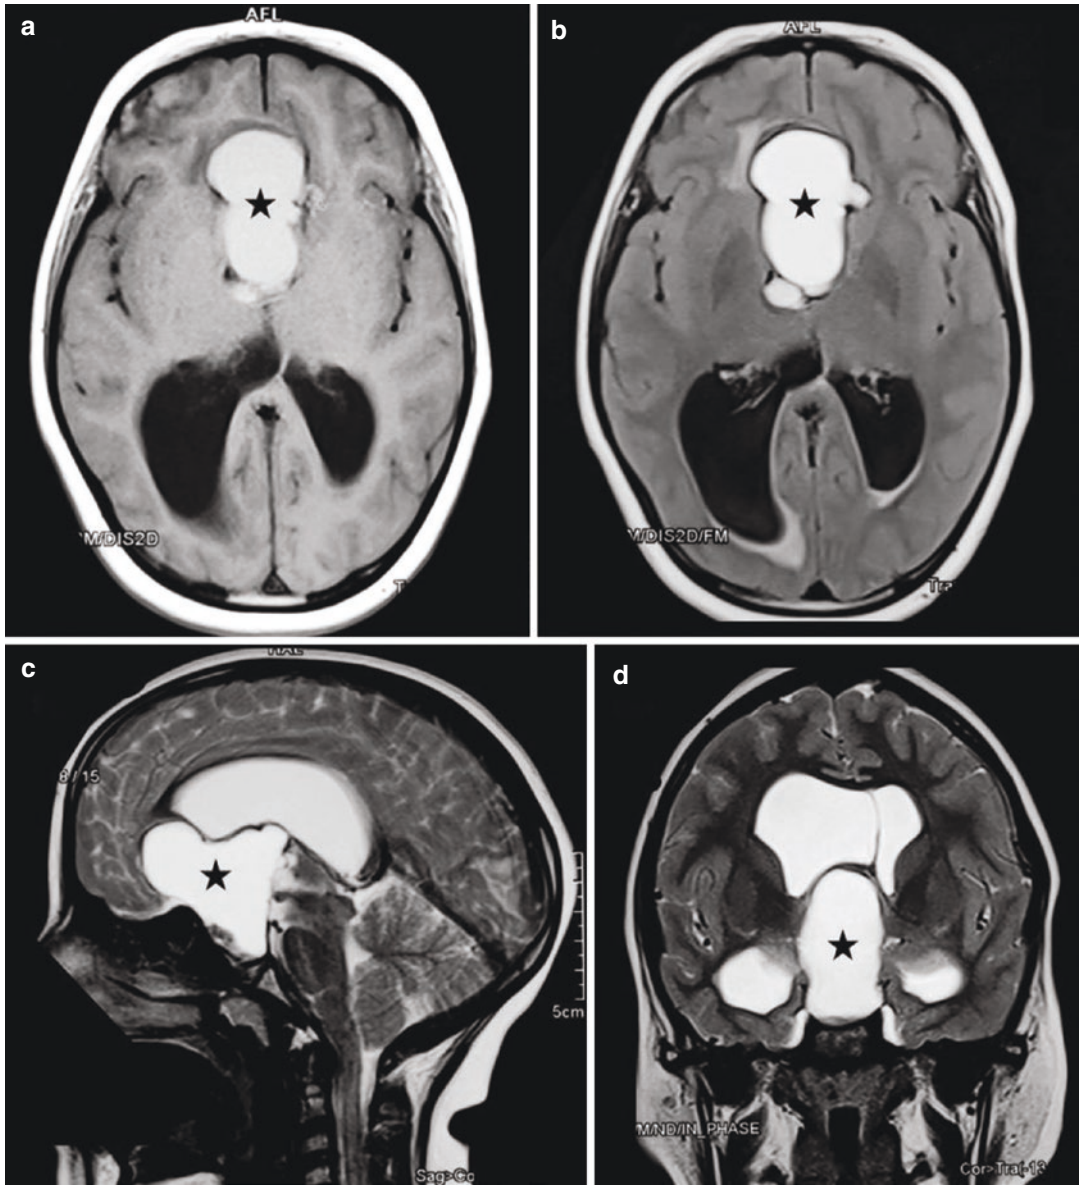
Case 2. Intra- and suprasellar cystic craniopharyngioma (stars). Axial T1- (a) and sagittal T2-weighted MR images (b). Axial FLAIR sequence (c) and 3D-CISS MR image (d)
